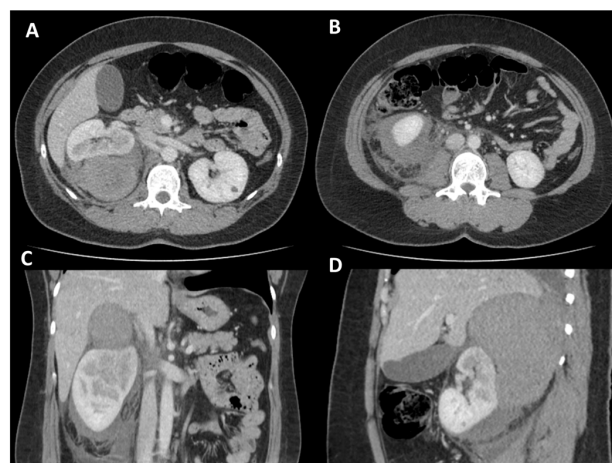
Abdominal CT scan: a spontaneously hyperdense lesion in the right perirenal area measuring around 127 x 91 x 75 mm (longitudinal x anteroposterior x transverse) with no definition of a bleeding vessel or clear identification of the lesion's origin, independent of the adrenal gland, which is compressed and maintains normal dimensions.
